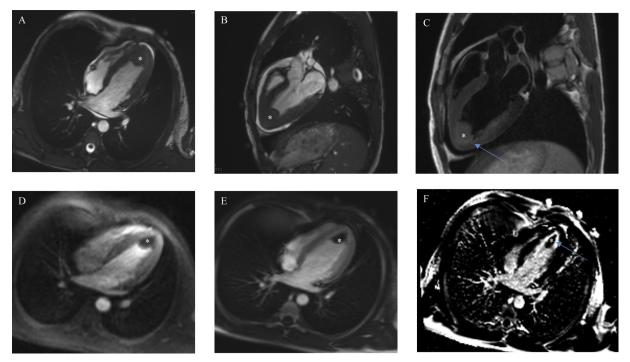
Cardiac magnetic resonance, (A) cine steady-state free precession (SSFP) four-chamber view and (B) cine SSFP threechamber view, showing a large 2.7-cm apical mass (asterisk) in the setting of normal wall motion and overall preserved left ventricular function and small pericardial effusion. (C) T2-weighted fast spin echo sequences with evidence of hyperintense signal in the apical and inferior myocardial wall adjacent to the thrombus suggestive of myocardial inflammation (blue arrow), (D) Resting first-pass perfusion images did not reveal any gadolinium uptake in the mass, suggesting absence of vascularity. Postgadolinium inversion recovery sequences performed with high inversion times (600 ms) in (E) four-chamber view and (F) two-chamber view revealed lack of delayed enhancement and homogeneously black appearance consistent with thrombus and adjacent apical myocardial inflammation.
